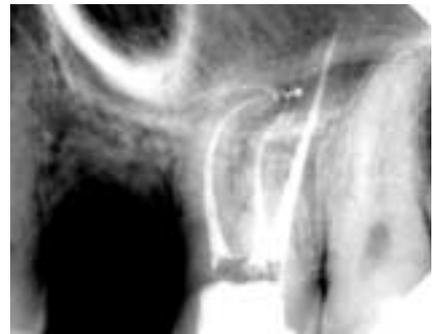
The purposes of maintaining patency and the ability to retain the intricacies of the curvature of the root canal space by using a crown down technique are demonstrated in this radiograph (courtesy of Dr. Fred Barnett).
